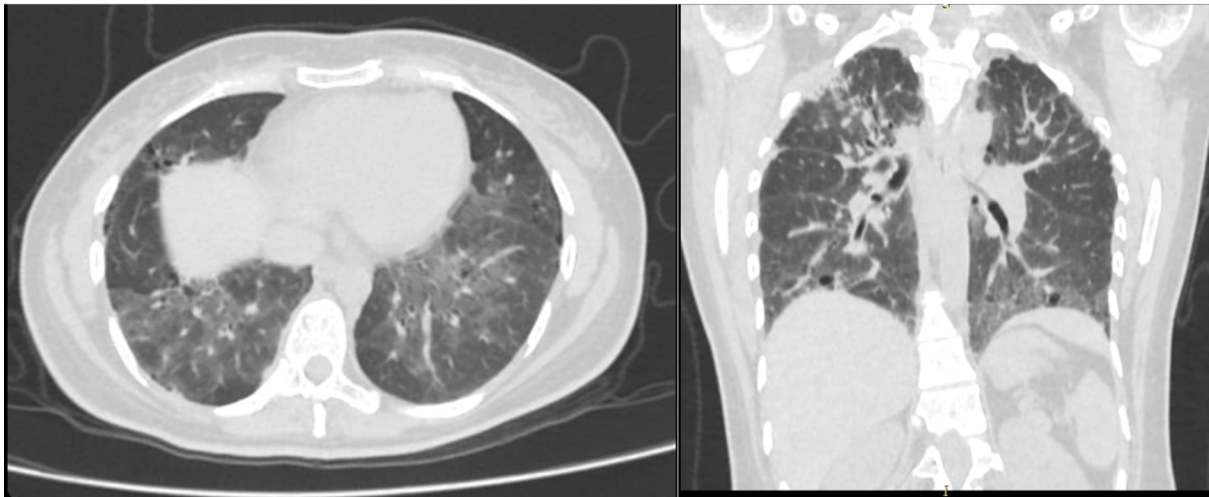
HRCT Chest coronal and axial images showing bilateral apical pleural thickening with ground glass haze and interspersed traction bronchiectasis suggesting interstitial lung disease.
